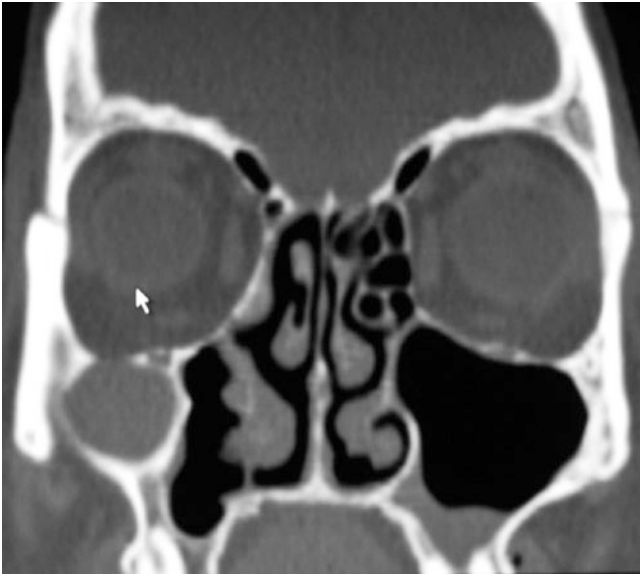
Surgical ciliated cyst of the maxilla: CT scan depicts a cyst in the lateral wall of the maxilla that expands to contact with the floor of the orbit (Courtesy of Dr. P. Claros, Barcelona, Spain)
